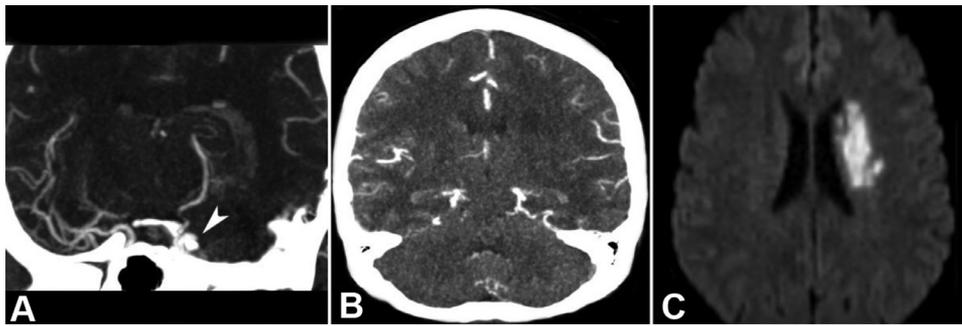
A case of good collaterals and small final infarct volume. 55-year-old woman who presented with NIHSS of 5. (A) A coronal CTA demonstrates a left M1 occlusion (arrow). (B) An axial CTA demonstrates a good collateral score (Tan score = 3) with equal amount of blood vessels visualized in both hemispheres. (C) Axial MRI DWI demonstrates a small stroke with a final infarct volume of 7.9 mL. Abbreviations: CTA, computed tomography angiography; DWI, diffusion weighted imaging; MRI, magnetic resonance imaging; NIHSS, National Institute of Health Stroke Scale.
